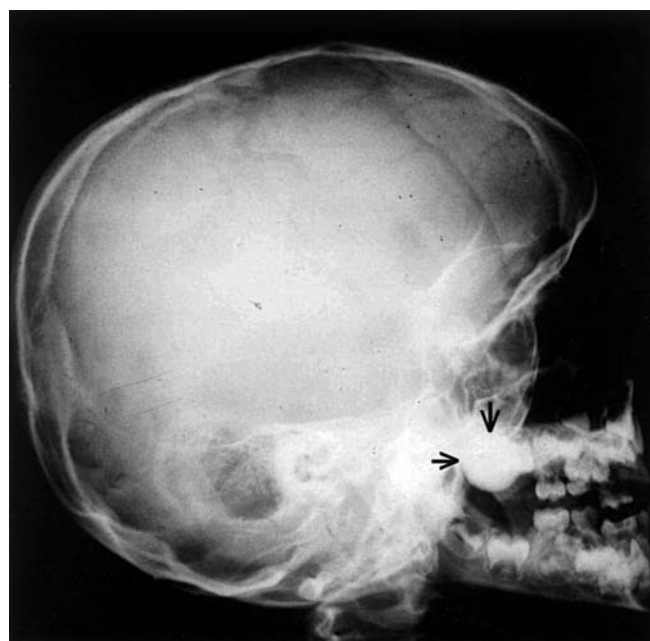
Impacted marble (arrows) is seen in the lateral plain film of the nasopharynx
